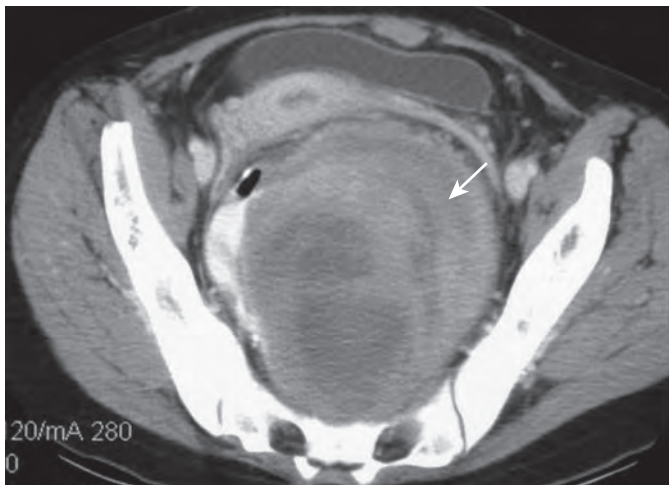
Mesenteric fibromatosis in a 25-year-old woman with familial adenomatous polyposis syndrome. She is status post total colectomy with ileoanal anastomosis. Intravenous and oral contrast-enhanced CT shows a large heterogeneous mass (arrow) arising in the small bowel mesentery adjacent to the ileoanal anastomosis.
